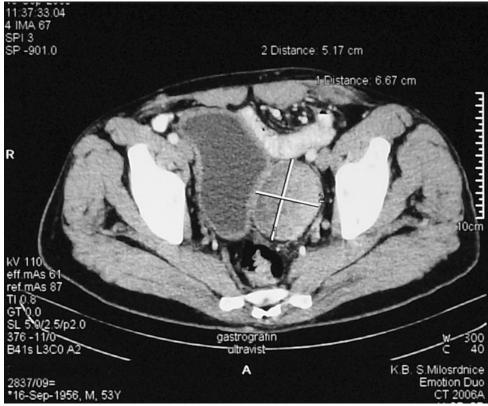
Pelvic CT scan showing a large bladder diverticulum containing an irregular contrast enhancing mass, causing impression on posterior left lateral aspect of the bladder.
